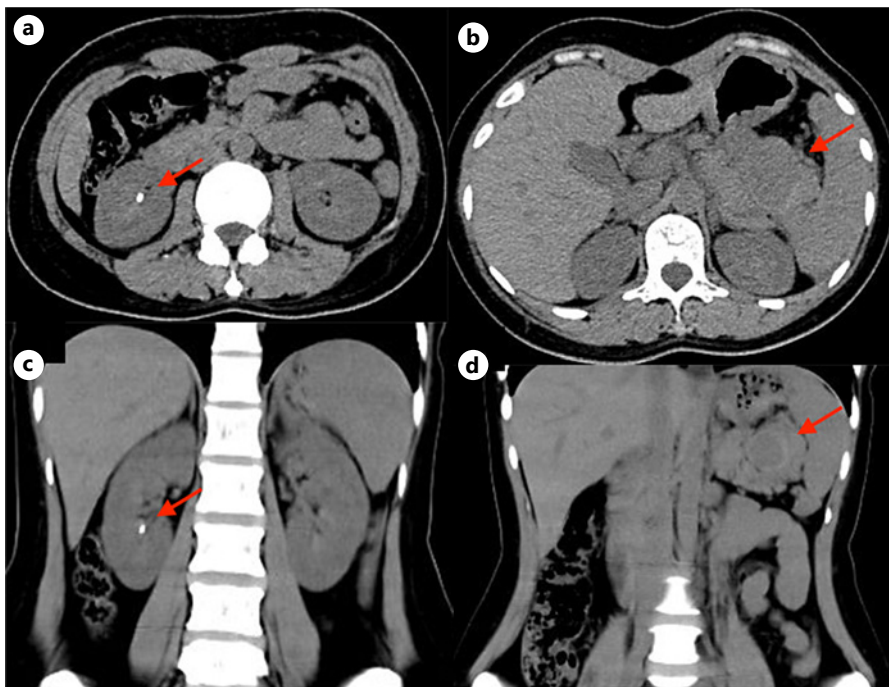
Abdominal plain CT findings: abdominal axial (a) and coronal (c) CT revealed a small stone in the right kidney (red arrow); abdominal axial (b) and coronal (d) CT revealed well-defined round mass in the gastropancreatic region measuring 17 mm in diameter, suggesting a splenic artery aneurysm (red arrow).
